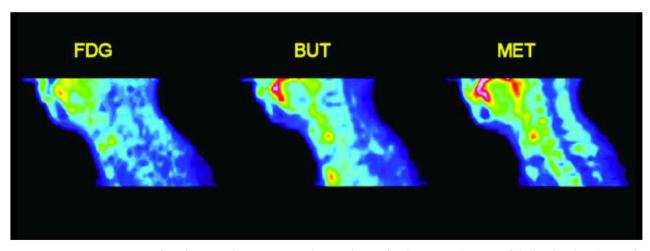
PET examinations of a reference subject not exposed to irradiation (median sagittal section of the head and neck region) reveal low FDG, [¹⁵O]butanol and [¹¹C]methionine accumulation within the cervical spinal cord segments.
